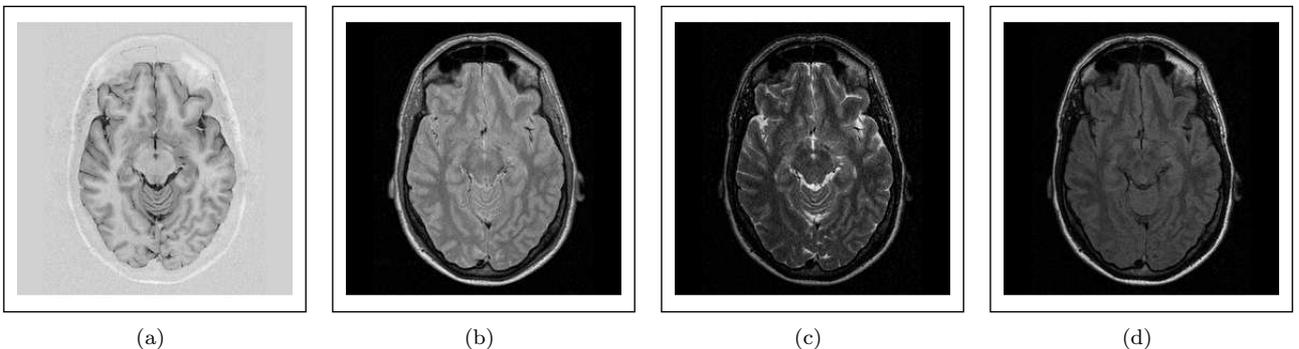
Original (legacy) data collected with Birdcage coil. (a) Inversion Recovery Turbo Spin Echo (IRTSE), (b) Variable Echo - Proton Density (VE-PD), (c) Variable Echo - T2 (VE-T2), and (d) Fluid-Attenuated Inversion Recovery (FLAIR)
